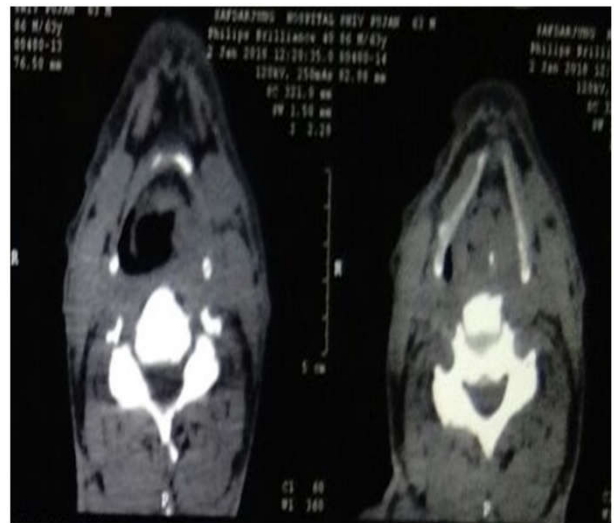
CT scan showing hypopharyngeal tumour with compromised airway.
